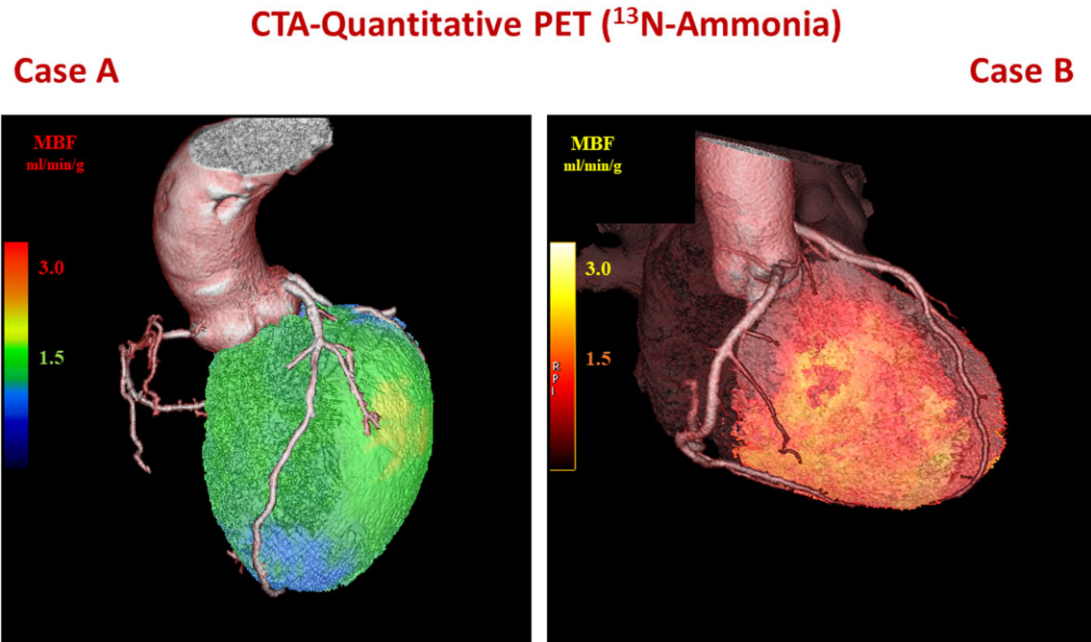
CTA-PET imaging. CTA-PET imaging in two patients with recent onset dyspnoea. Case A is a 67 years old man with multiple risk factors, LBBB, systolic LV dysfunction (LVEF 30%), and diffuse non-obstructive CAD at CTA. Case B is a 60 years old man with glucose intolerance, mild hypertension, systolic LV dysfunction (LVEF 33%), and normal coronary arteries at CTA. In both cases, quantitative hyperaemic (after i.v. dipyridamole) myocardial blood flow values with N-13 ammonia PET are globally reduced (normal values > 2 mL/min/g, please note different colour codes have been used in these cases) (see also Ref.²¹ Liga *et al.* and Ref.²⁴ Neglia *et al.*).
